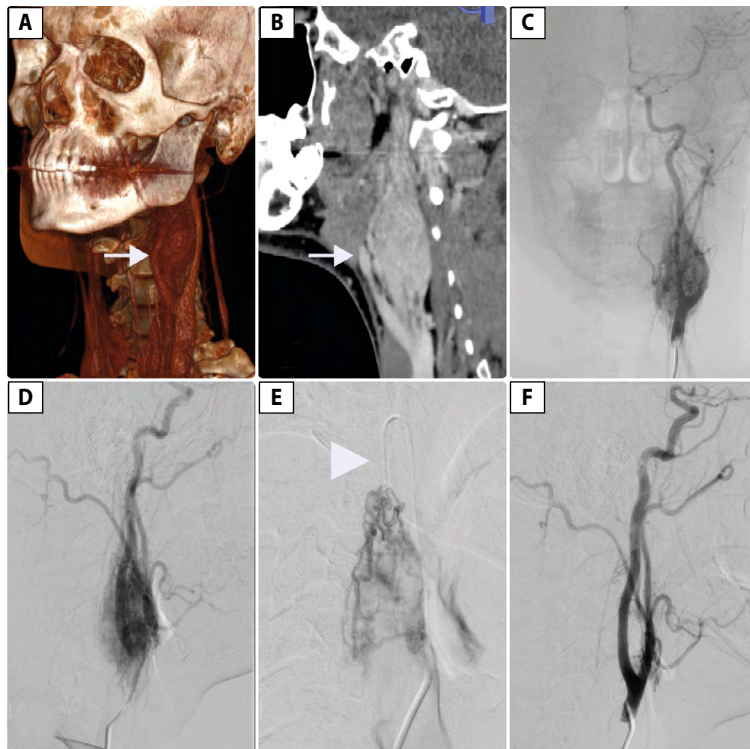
19-year-old male patient diagnosed with left-sided carotid body paraganglioma (white arrow): A – CT 3D reconstruction, B – sagittal view of contrast-enhanced CT. Diagnosis was confirmed in DSA (C, D). Selective catheterisation and embolisation of arterial feeders was performed with particles (E – white arrow). Control DSA confirmed complete occlusion of lesion (F)
